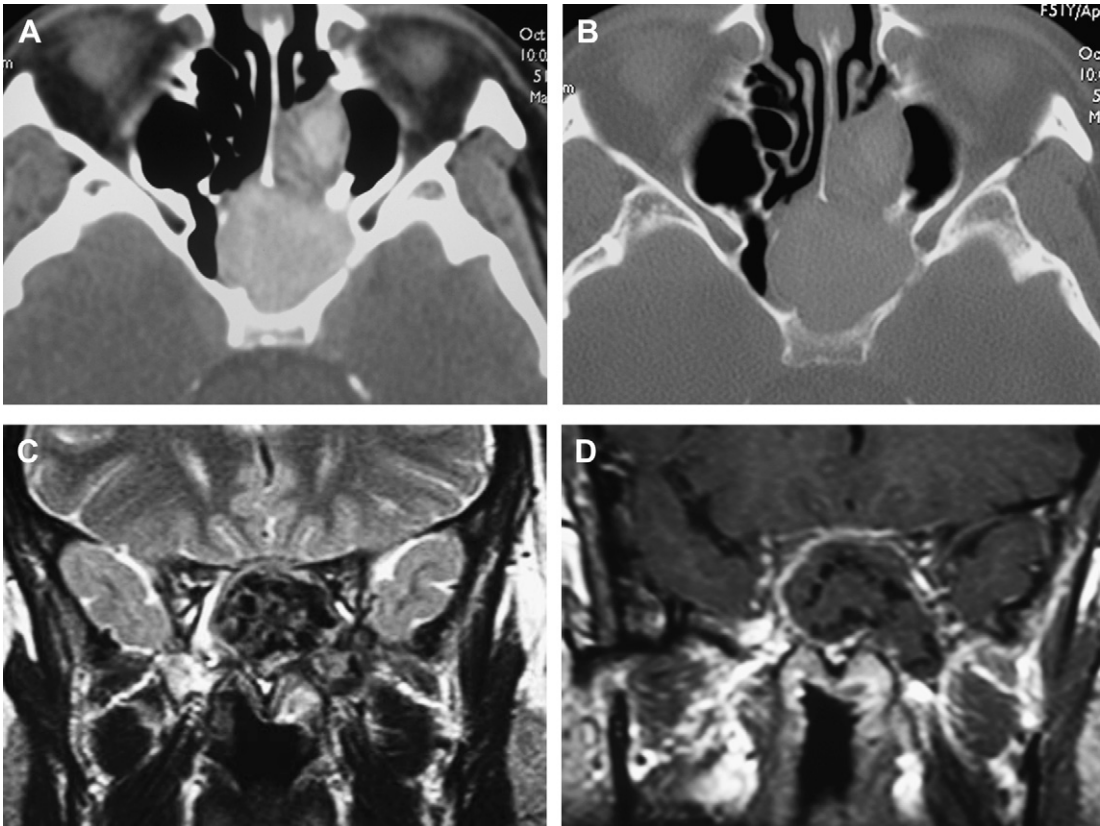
Axial CT scan in soft tissue (A) and a bone algorithm (B) shows a heterogeneous but mostly spontaneous hyperdense mass filling in and expanding the right sphenoid sinus and posterior ethmoid cells. Note the thinning and remodeling of the bony walls of the sphenoid sinus without elements of frank destruction, suggestive of a slow-growing process. Corresponding MR imaging, coronal T2-weighted image (C) and gadolinium-enhanced coronal T1-weighted image (D), show that the material filling in the sinus is markedly heterogeneous, predominantly of low signal intensity on T2-weighted images, with serpiginous areas of signal void. Only peripheral enhancement is noted after gadolinium administration (sphenoid sinus mucocele superinfected by fungal hypha-mycetoma).
